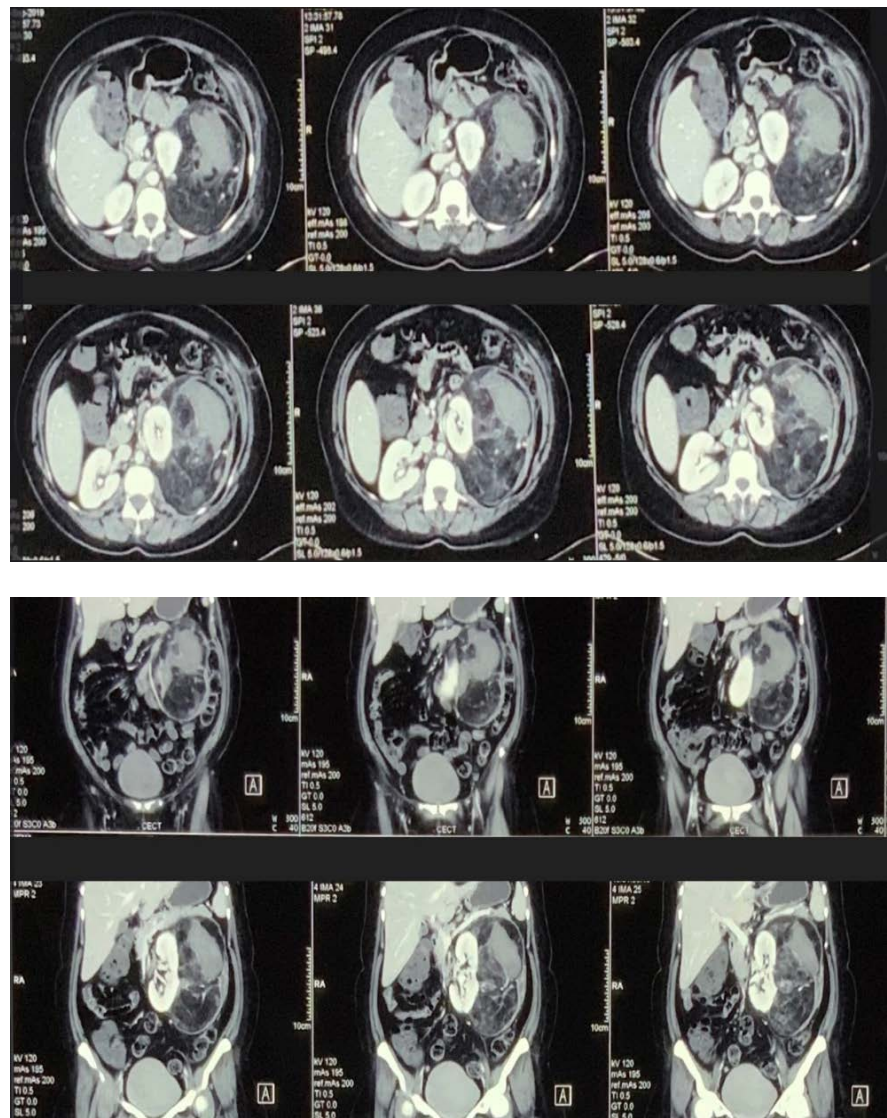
Axial and coronal views of contrast enhanced computed tomography showing large mass arising from left kidney laterally indenting its surface with negative 20 Hounsfield values (suggestive of fat) with a large area of hemorrhage within the tumour.
